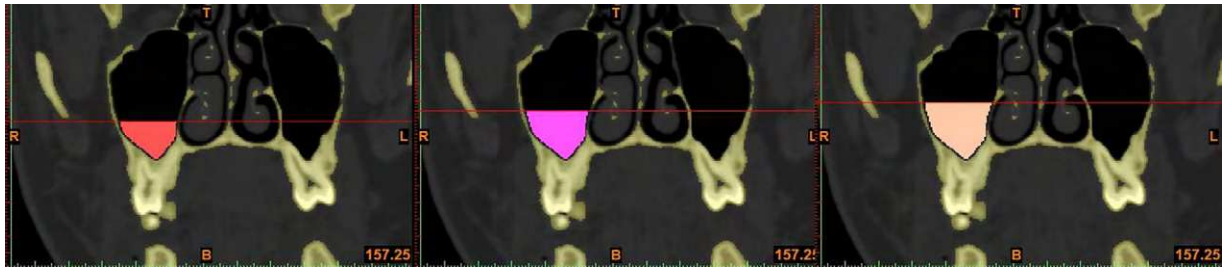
CT slices show sinus lift augmentation levels 12, 15 and 18 mm, respectively.
